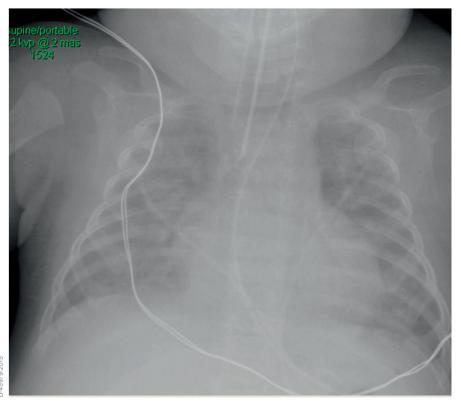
X-ray after intubation
